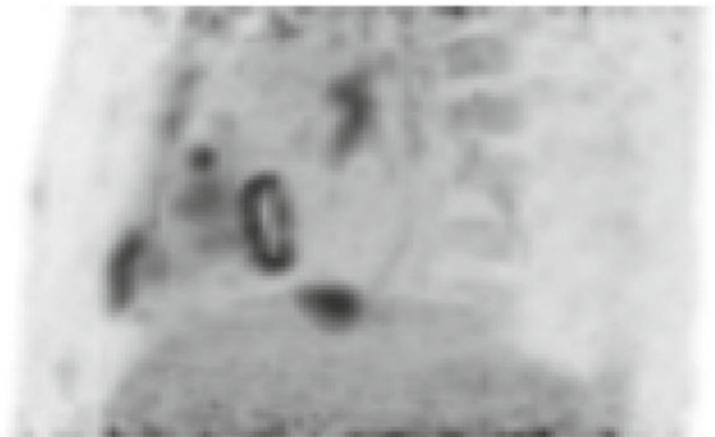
^{18}F -FDG PET, 3D MIP demonstrating tumor infiltration in the tricuspid annulus and right ventricular apex in the same case as Fig. 1.9
